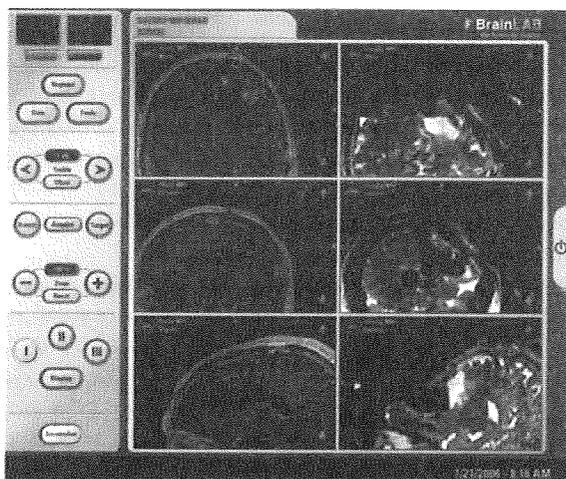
Comparison of MRI image on neuro-navigation display (Left: preoperative axial, coronal, and sagittal views on T1WI. Right: intraoperative axial, coronal, and sagittal view on T2WI). Note remarkable "brain shift" after connection of ventricle with tumor removal cavity.
